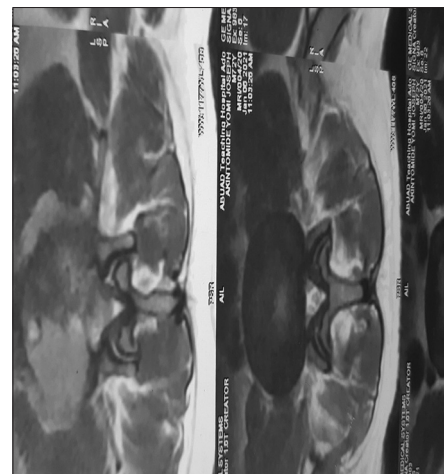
MRI axial view showing irregularity and heterogeneity of the L3/L4 disc material
